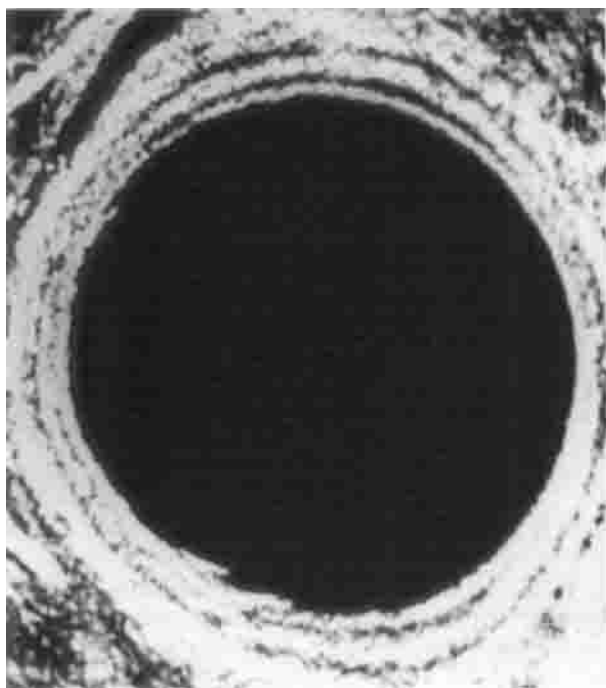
Sonographic layers of the rectal wall.
